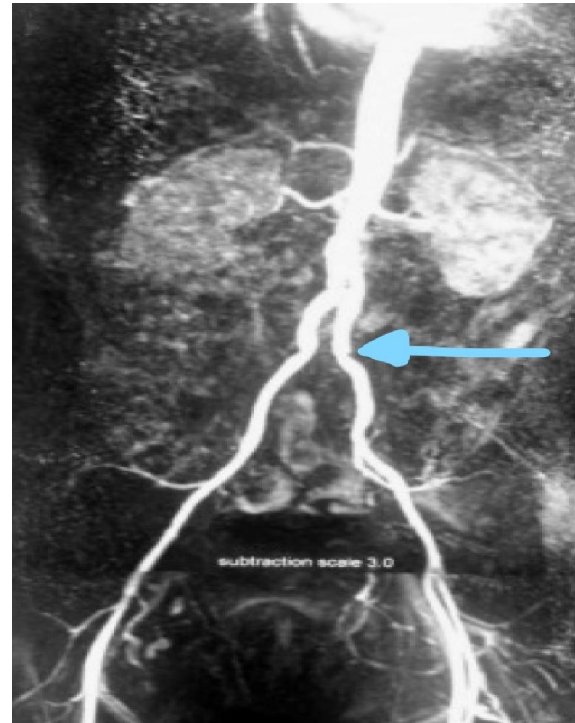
Follow-up CTA of aortobi-iliac graft to exclude any possible kink, stenosis, or aneurysmal dilation of the graft, arrow shows site of iliac anastomosis.
